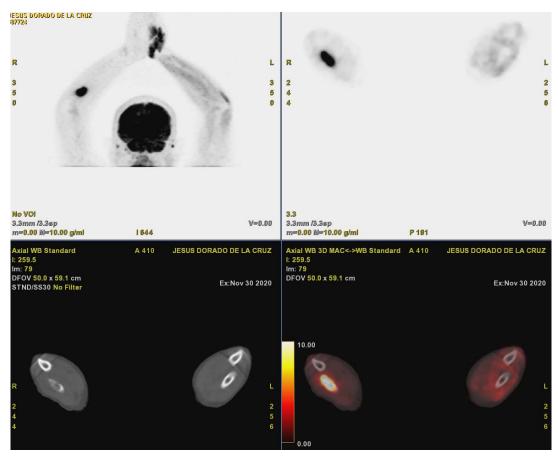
PET TAC image showing an intense increase in metabolic activity in a lytic lesion in the right proximal radius (SUV max 17.8)
